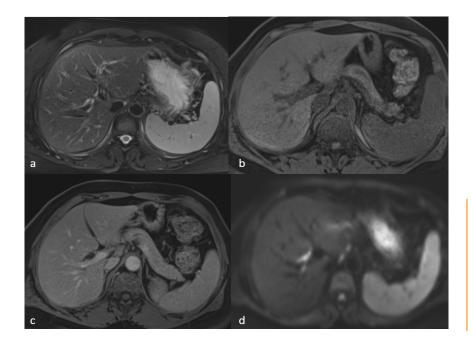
The follow-up magnetic resonance imaging after antitubercular treatment shows complete resolution of the lesions across all sequences, including A) T2-weighted, B) fat-saturated T1-weighted sequences before and C) after gadolinium injection, as well as on D) diffusion-weighted imaging.
